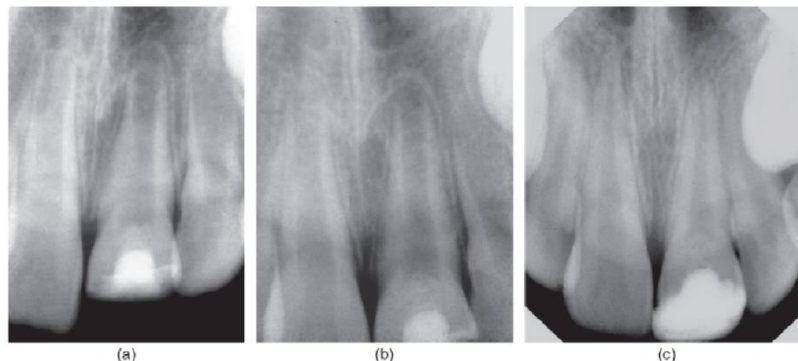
Cervical Pulpotomy on a maxillary left central incisor with an open apex. (a) Radiograph 3 months after pulpotomy. Note the dentin bridge. (b) Radiograph 6 months after pulpotomy. The dentin bridge has thickened. (c) Radiograph 3.5 years after Cvek pulpotomy. The root formation is completed and the apex closed. The dentin bridge has thickened but the root is free of abnormal calcification (Hafez, *et al.*, 2002).
